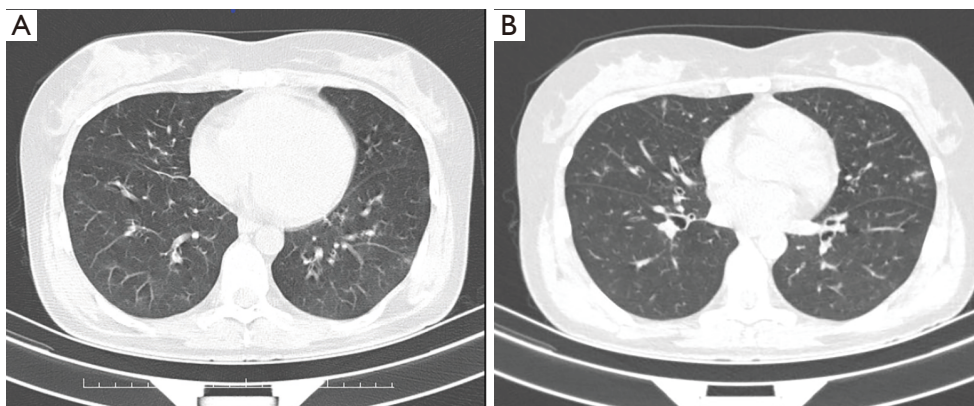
Two different levels of chest computed tomography scanning on admission for obvious diminution of small multiple small patchy and high-density nodules.
